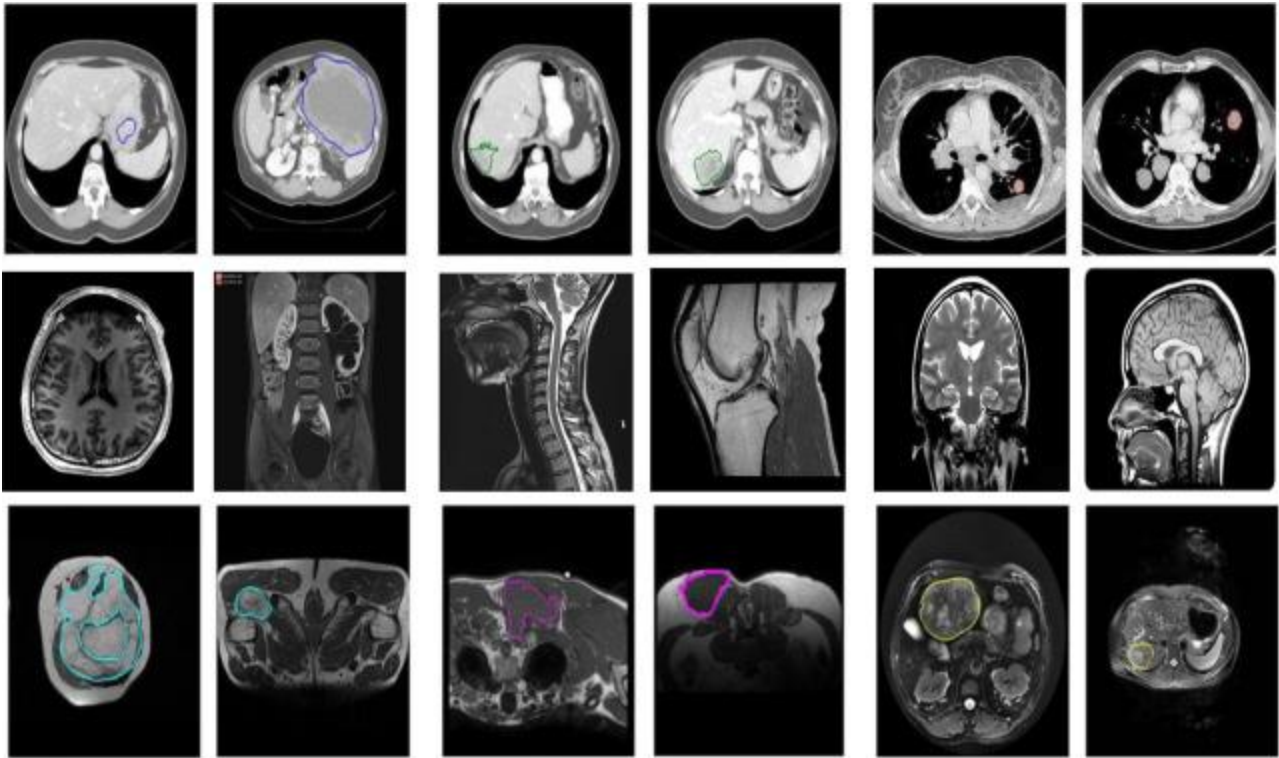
Sample test images from MRI medical dataset.
